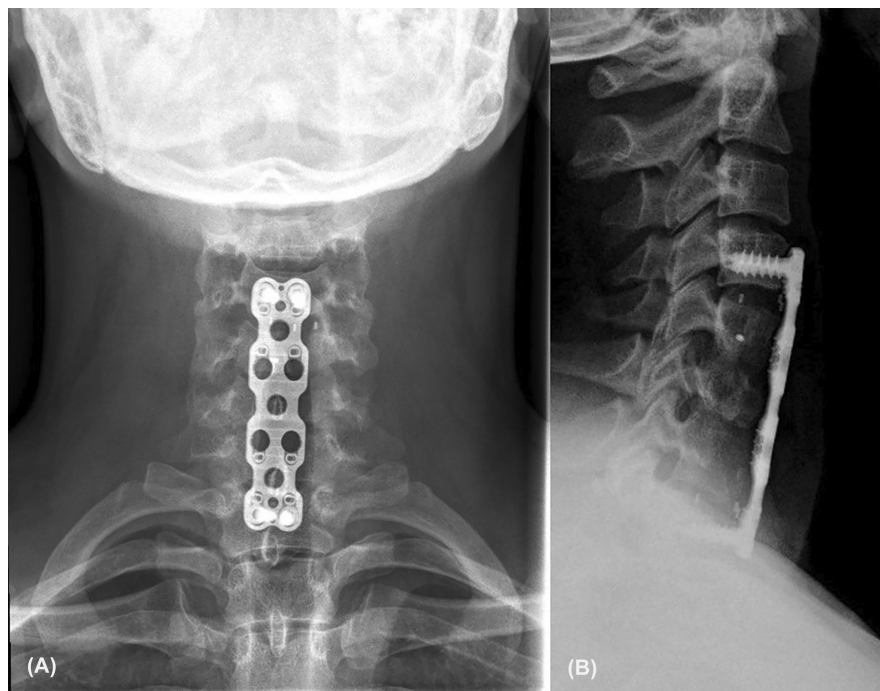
(A) AP view of the cervical spine X-ray showing a good position of the instrumentation. (B) Lateral view of the cervical spine X-ray showing good alignment with a reduction of the kyphosis and satisfactory fusion.
